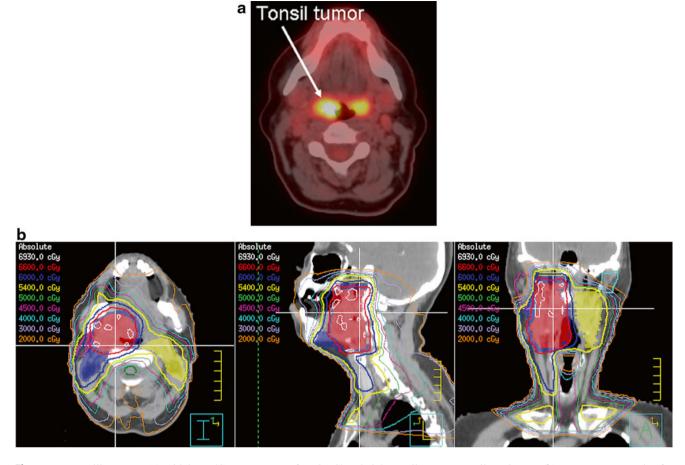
Tonsillar tumor. (a) Initial PET/CT appearance of a T2 N2b M0 right tonsil squamous cell carcinoma. (b) IMRT treatment plan for definitive radiation of this lesion to a dose of 66 Gy in 30 fractions with concurrent cetuximab
